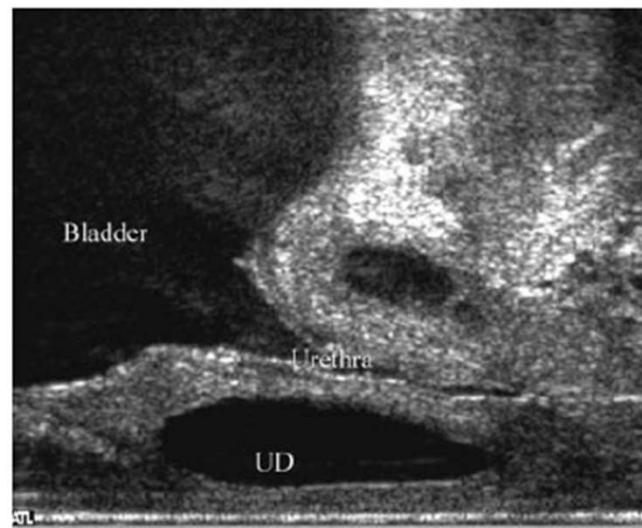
Urethral diverticulum (case 2). Midsagittal TVUS sonogram shows the urethral diverticulum (UD) posterior to the urethra (U). B, bladder.
